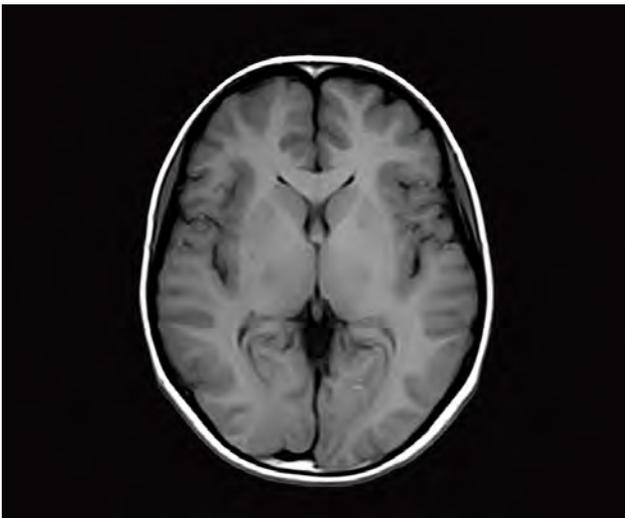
Axial MRIs of the brain. Left: T1-weighted image (short TE and TR). Right: T2-weighted image (long TE and TR).
